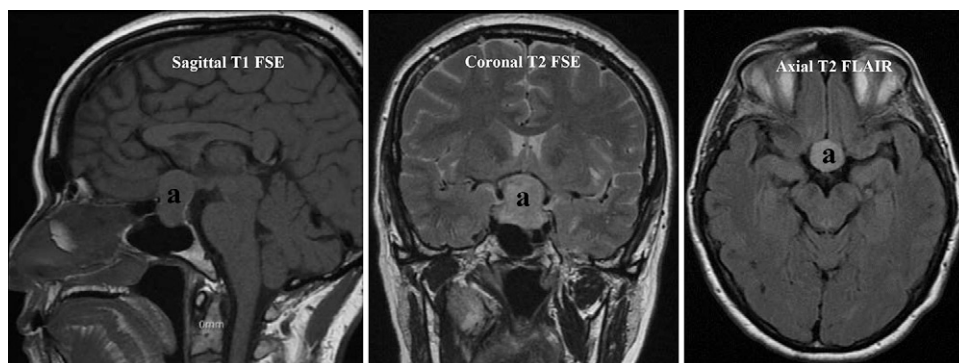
Brain MRI scans showing a pituitary macroadenoma (a) with small foci of bleeding and signs of compression of the optic chiasm. FLAIR = Fluid-attenuated inversion-recovery; FSE = fast spin echo.
